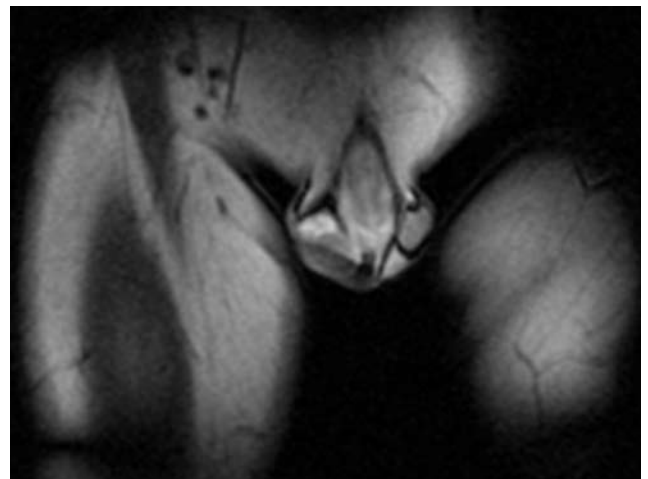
Dynamic contrast enhanced MRI image of testicles of a patient with right-sided epididymitis. Uptake of the gadolinium in the right epididymis is enhanced, but the testicles themselves show equal signal intensity.
